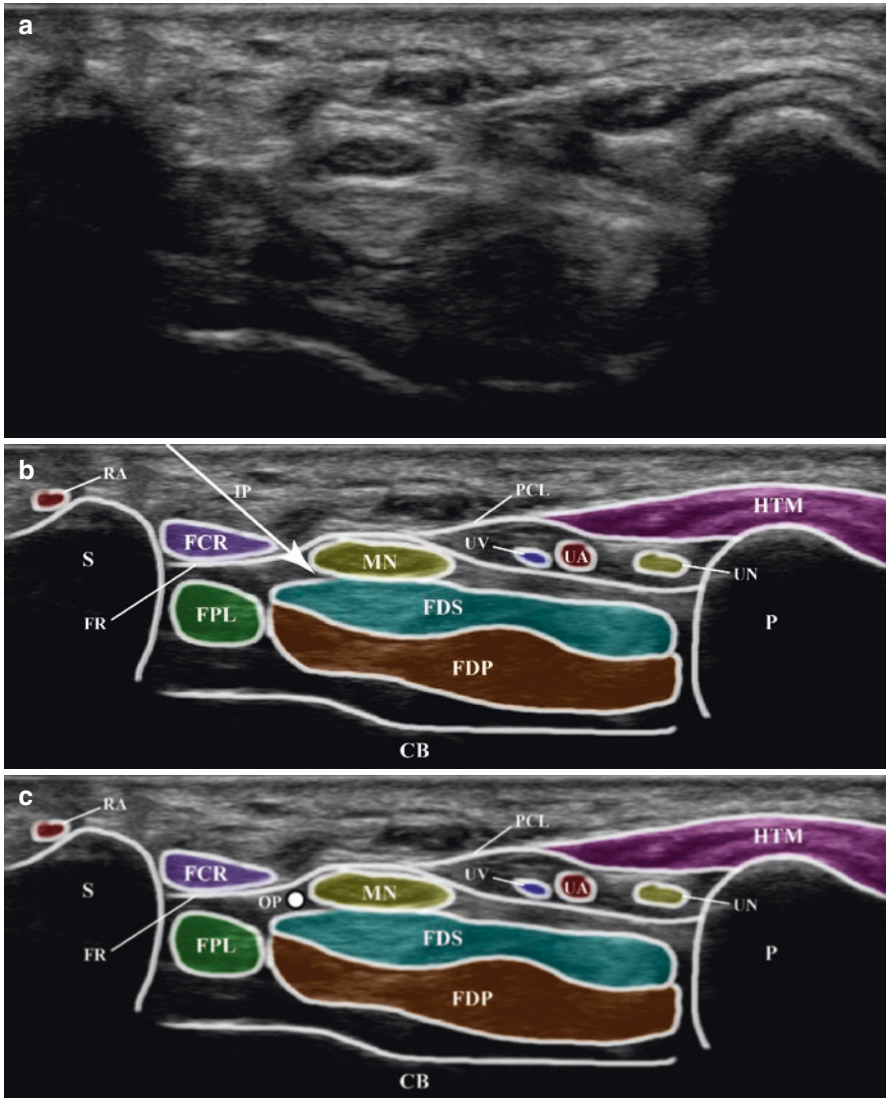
(a) Needle trajectory for in-plane (IP) ultrasound guided carpal tunnel injection. (b) Needle trajectory for out-of-plane (OP) ultrasound guided carpal tunnel injection
